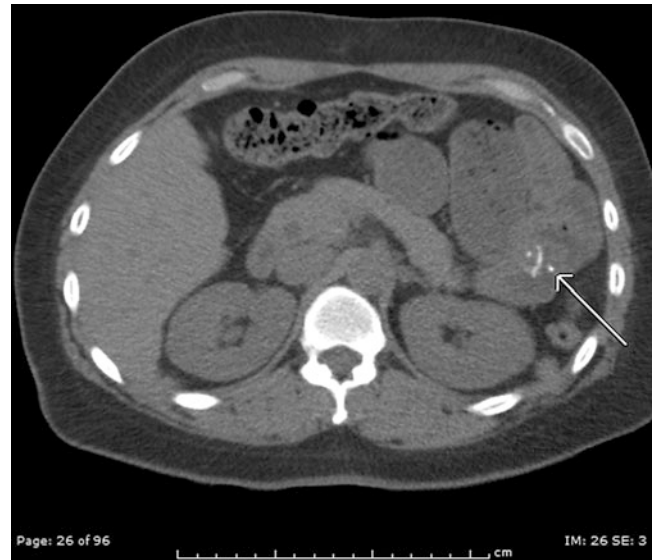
Axial CT showing jejunojejunal anastomosis as site of obstruction
